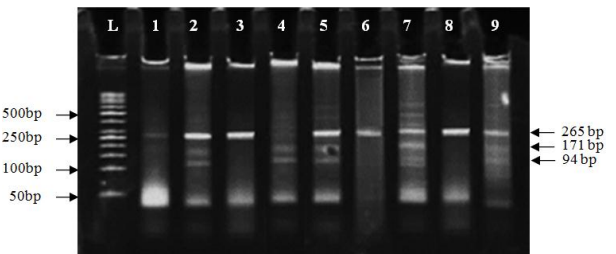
RFLP analysis of C677T mutation in infertile subjects detected by 8% native poly acrylamide gel electrophoresis (PAGE). The 265 bp PCR product was digested with *HinfI*. Lane L: GeneRuler 50 bp DNA ladder (Fermentas # SM0371); lane 1, 3 and 8: CC homozygous, lane 4: CT heterozygous mutation; lane 2, 5, 7 and 9: TT homozygous mutation.
